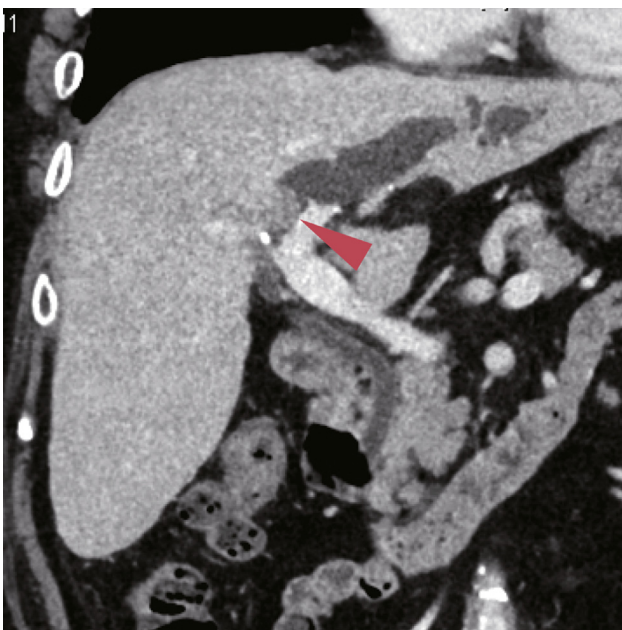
Contrast-enhanced CT showed an iso-enhanced small tumor in the hilar bile duct and dilation of the left intrahepatic bile duct.
